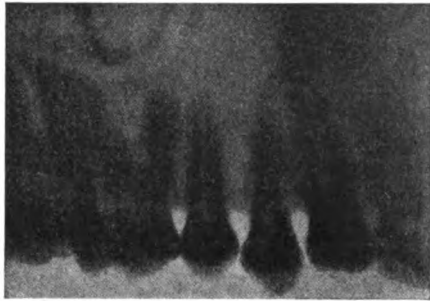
Radiograph of the teeth made with endodiascope inside the mouth and the film outside.
